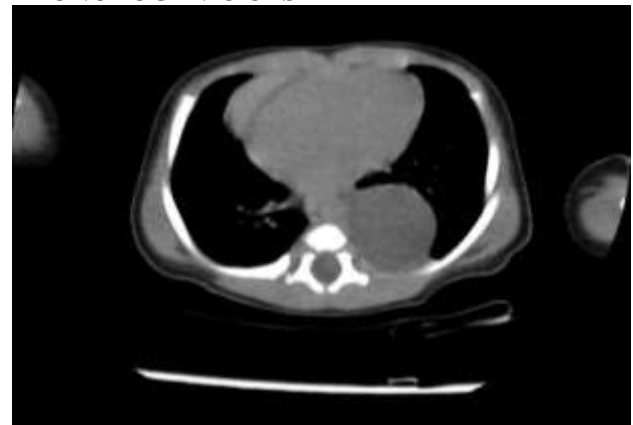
Axial CT of thorax in a 12 days old baby showing bronchogenic cyst.
